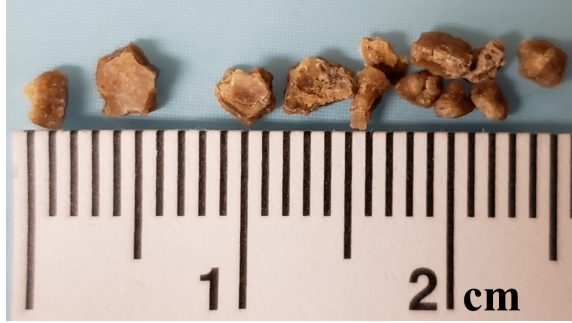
Examples of small *ex vivo* kidney stones, to demonstrate the wide variety of shapes they can take. Figure ©2022 Ultrasonics.
